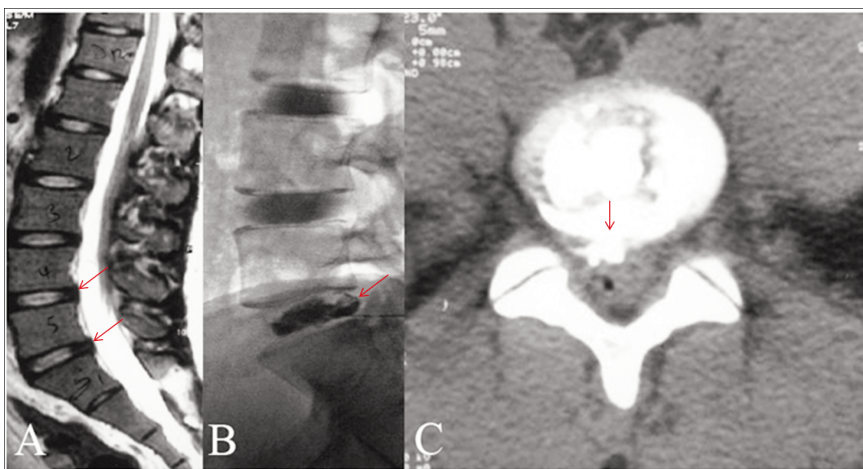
A) Sagittal T2-weighted magnetic resonance imaging showing only mild bulging of L4-5 and L5-S1 intervertebral discs; B) Discography revealing an annulus fibrosus tear in the L5-S1 disc; C) computed tomography discography showing contrast material in the spinal canal.
